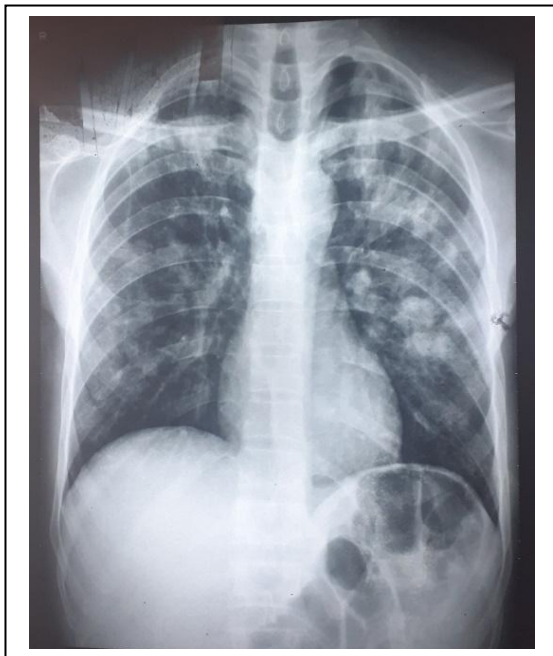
Chest X-Ray P/A view showing patchy opacities in upper, middle and lower zone of lungs
